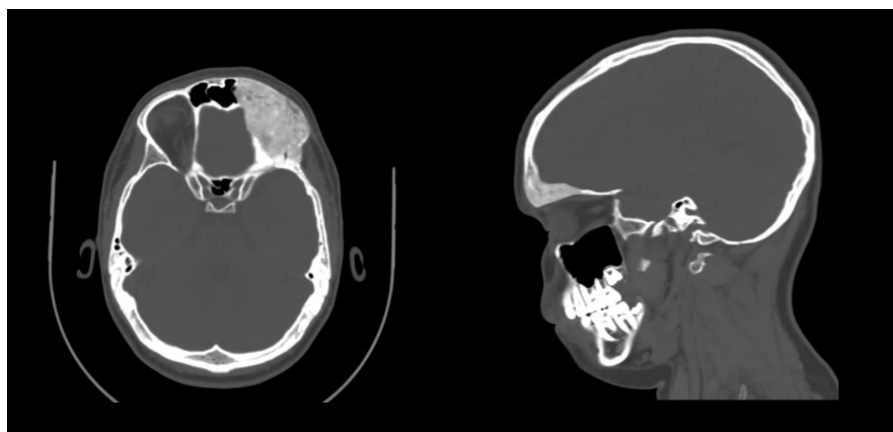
Axial and sagittal computed tomographic image exhibiting characteristic ground-glass opacification of fibrous dysplasia involving the left frontal bones in 2025
